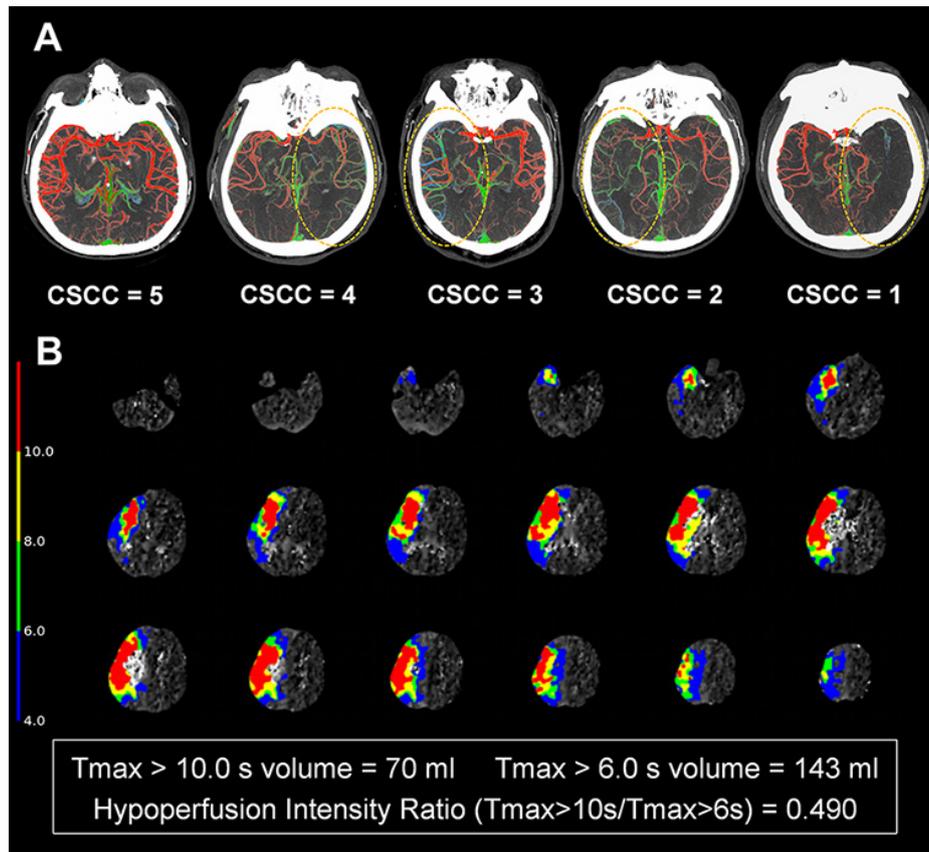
Example of evaluation of CSCC on mCTA and HIR on CTP imaging. CSCC, Collateral Score on Color-Coded summation maps; CTP, computed tomography perfusion; HIR, hypoperfusion intensity ratio; mCTA, multiphase computed tomography angiography; Tmax, time to maximum.
